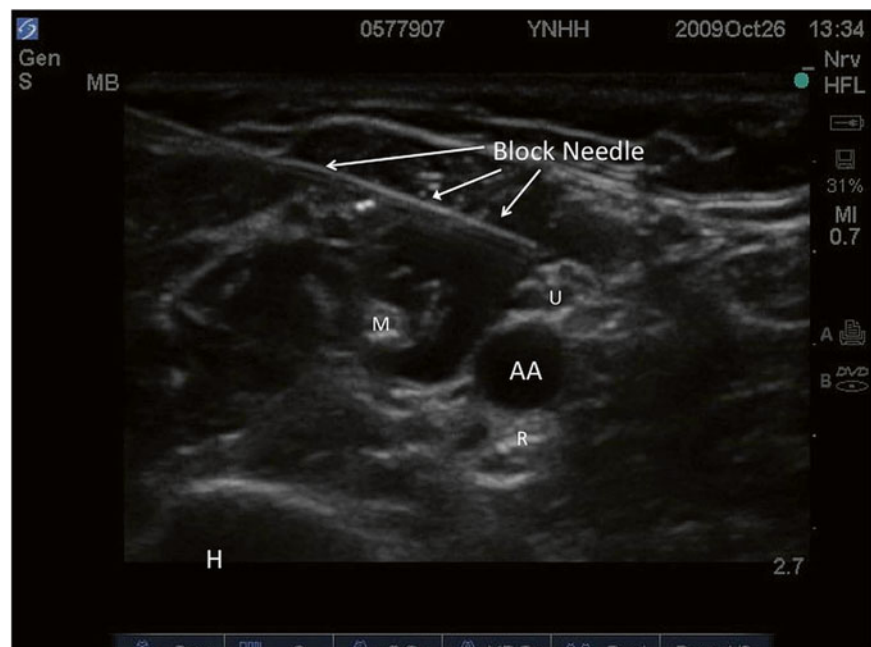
Ultrasound probe is positioned high in the axilla (intersection of pectoralis major with the biceps muscle). At this level, the axillary artery and all the three main nerves to be blocked (median, ulnar, radial) should be in view on the ultrasound image
